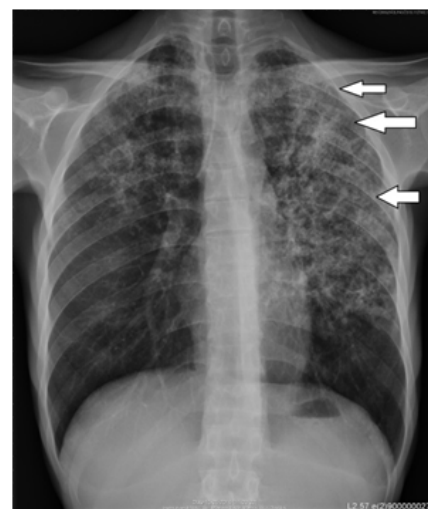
Chest X-ray with multiple bilateral variable-sized confluent lung nodules
